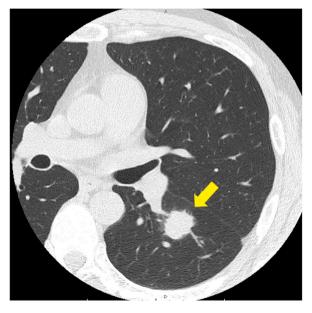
Chest computed tomography image demonstrating a solid nodule (arrow) measuring 21×20 mm in diameter in the superior segment (S6) of the left lower lobe.
